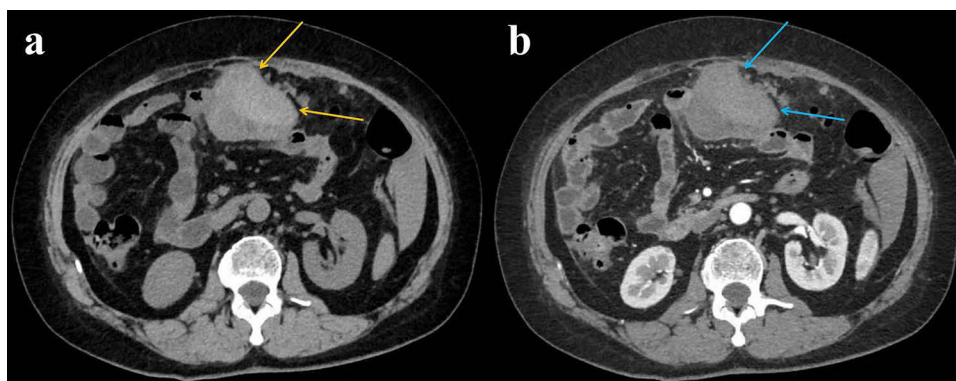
Abdominal computed tomography shows a slightly high-density heterogeneous mass of 9.3 * 5.9cm in the small intestine, with a density ranging from 34 to 57HU, indicated by yellow arrows (a). Enhanced scanning shows mild heterogeneous enhancement of the tumor, indicated by blue arrows (b).
